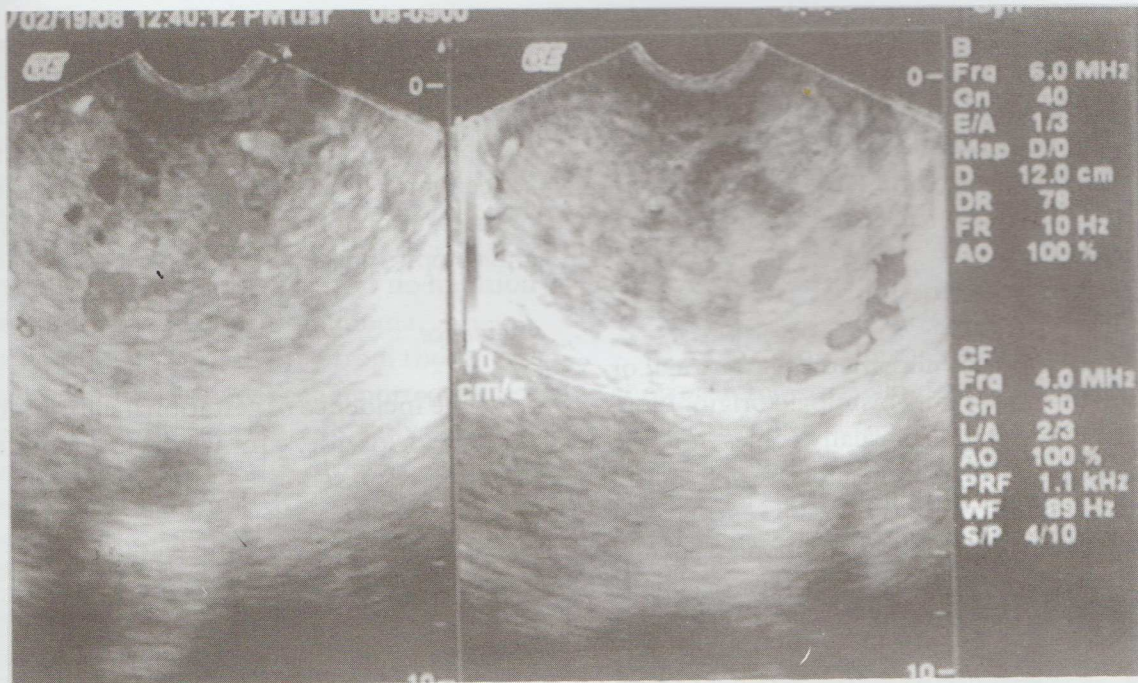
Transvaginal ultrasound with color flow of the cervical mass.
